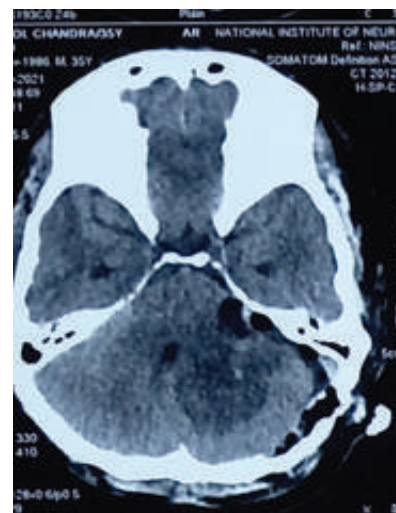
Postoperative CT scan of VS of same Patient
